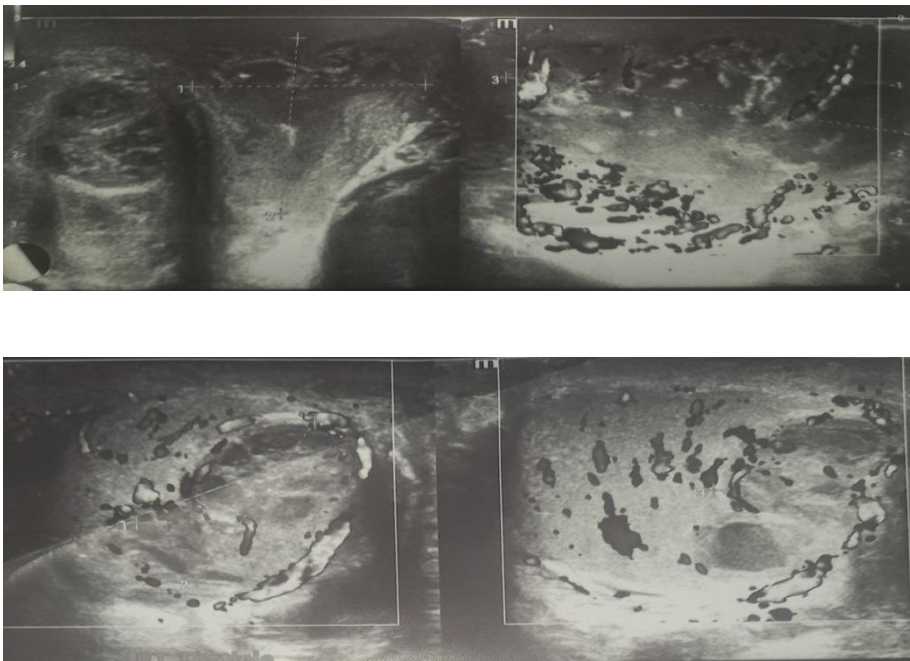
Inguino scrotal ultrasound (prior to treatment initiation).
